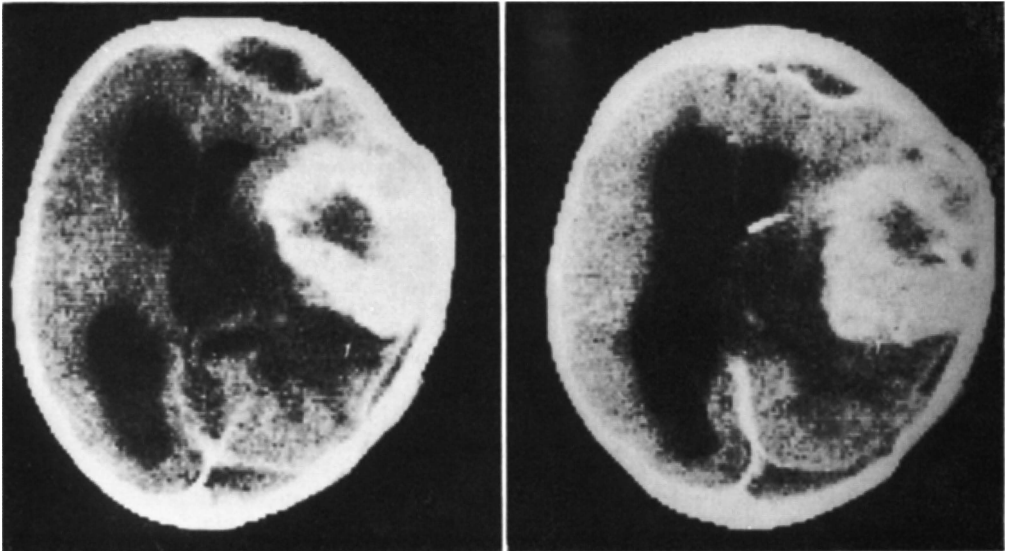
Case ACF. Contrast-enhanced CT scan. Large right frontotemporal mass with irregular hypodense areas, and shift of the supratentorial ventricles to the left.
